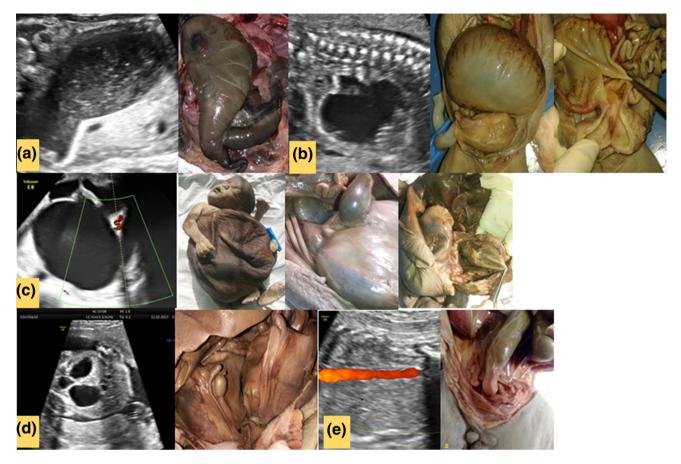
Autopsy correlation with ultrasound findings. a Retort shaped pelvic mass on ultrasound, b Fetus had mass with fluid-debris level on ultrasound and a common cloaca with distended large bowel, c A large cystic mass suggesting bladder outlet obstruction had an obstructed common cloaca and obstruction at bowel connection, d Ultrasound showed a small bladder and two elongated, closely
